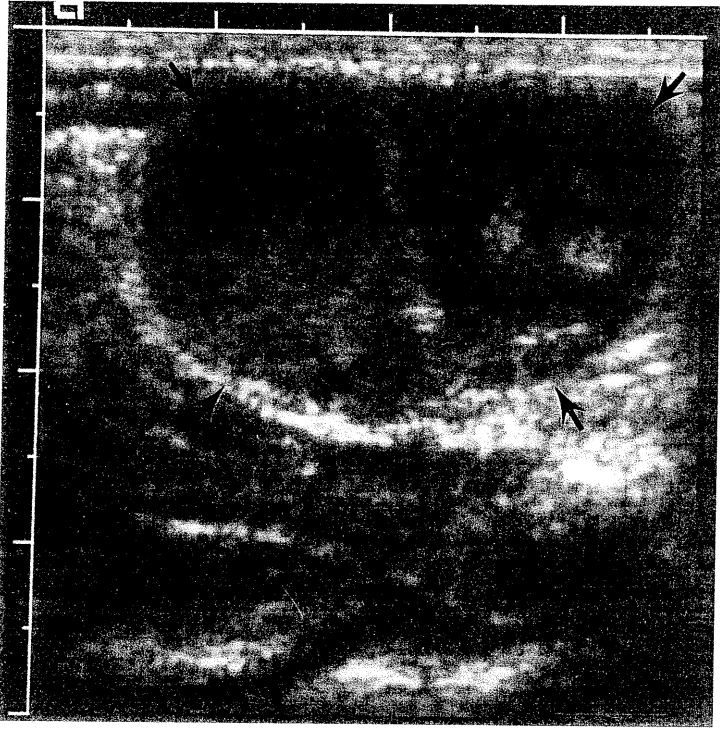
Abdominal ultrasonogram of abscessed mesenteric lymph node (margins delineated by arrows) from a white-faced saki (*Pithecia pithecia*) infected with *Mycobacterium avium-intracellulare* complex.
